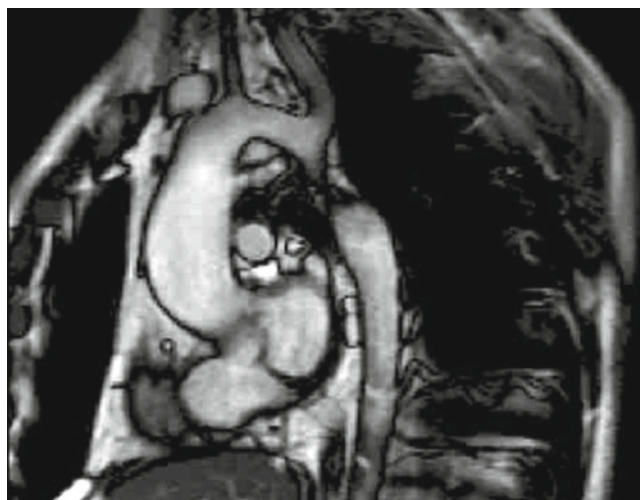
Magnetic resonance imaging of native coarctation of the aorta. Note moderate ascending aortic dilatation secondary to presence of a bicuspid aortic valve. Also marked dilatation of left subclavian artery due to significant collateral blood flow (Image courtesy of PJ Kilner)
